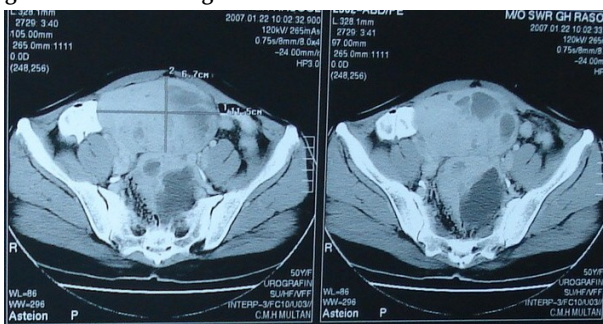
CT Scan Pelvis Showing Krukenberg Tumour
